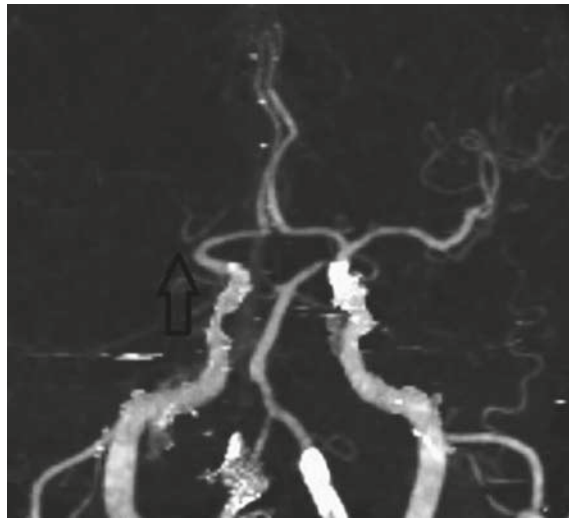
Initial imaging workup upon arrival at the general hospital. CT angiography (CTA) shows right M1 occlusion (arrow).
